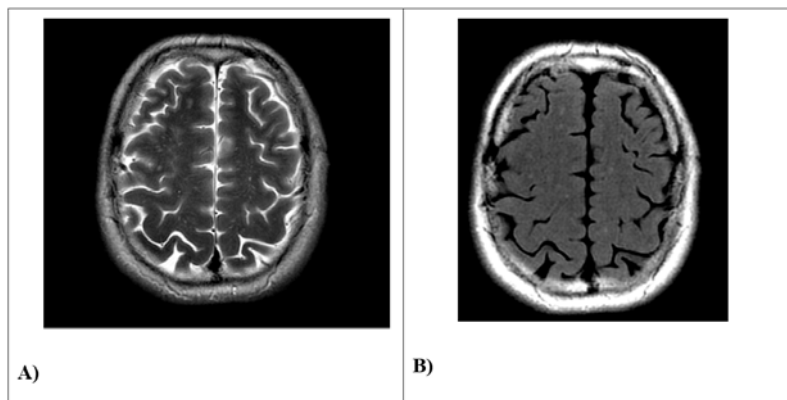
Brain MRI: A) frFSET2, B/FLAIRT2, axial plane. Signs of discrete cortical atrophy in the coronal and occipital regions on both sides. Punctate hyperintensive foci in the subcortical white matter of the both brain hemispheres indicating small vessel disease.
